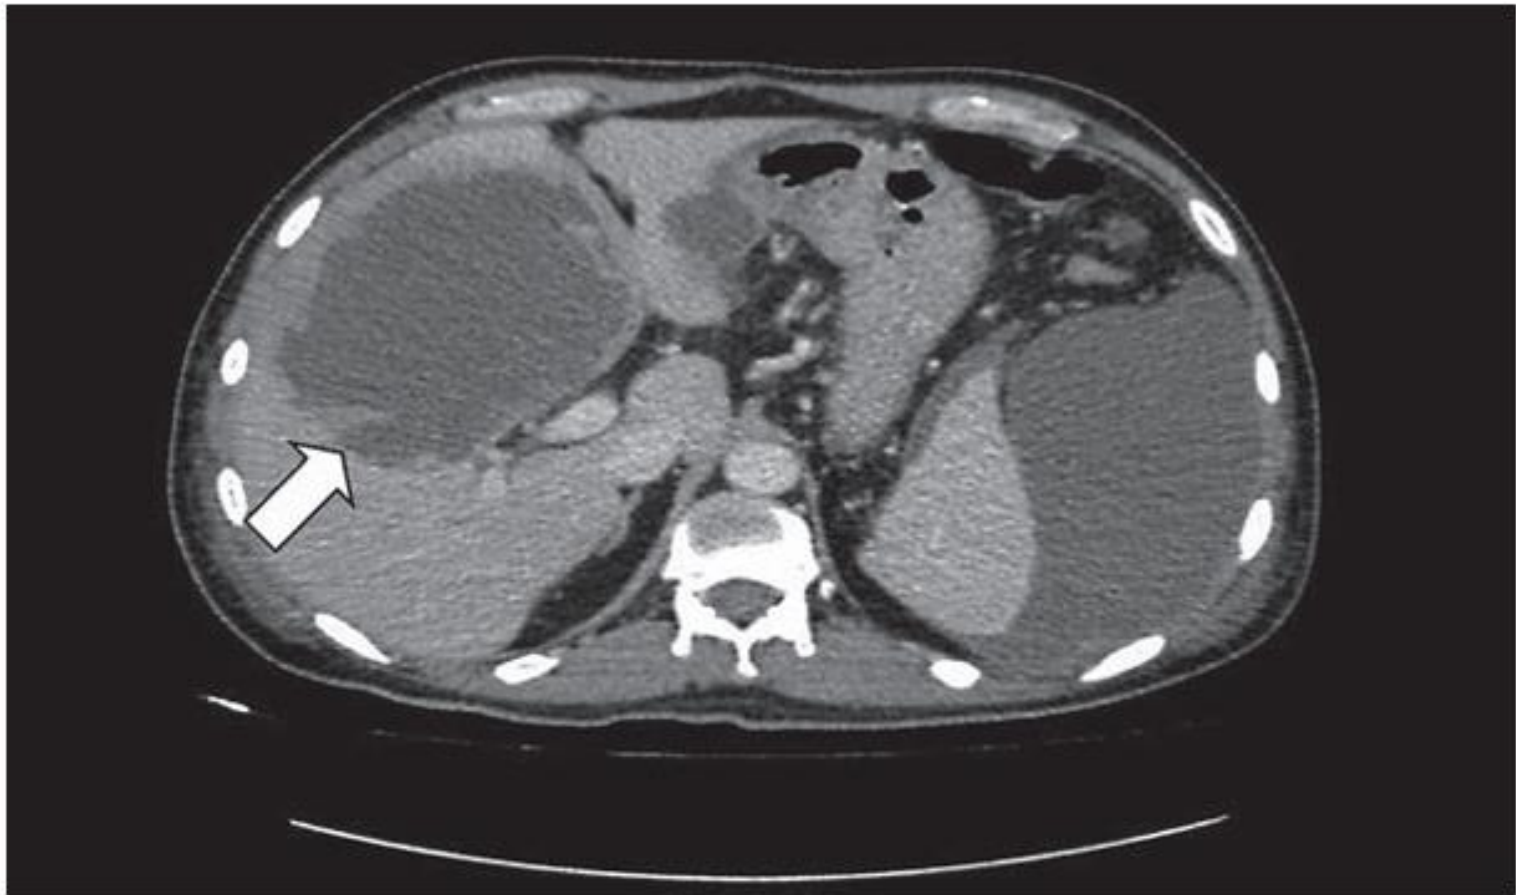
Computed tomography liver 4 phases revealed a well-defined lobulated hypodense lesion with no significant enhancement in the right lobe of the liver measuring approximately 11×9×10.4 cm (arrow).
